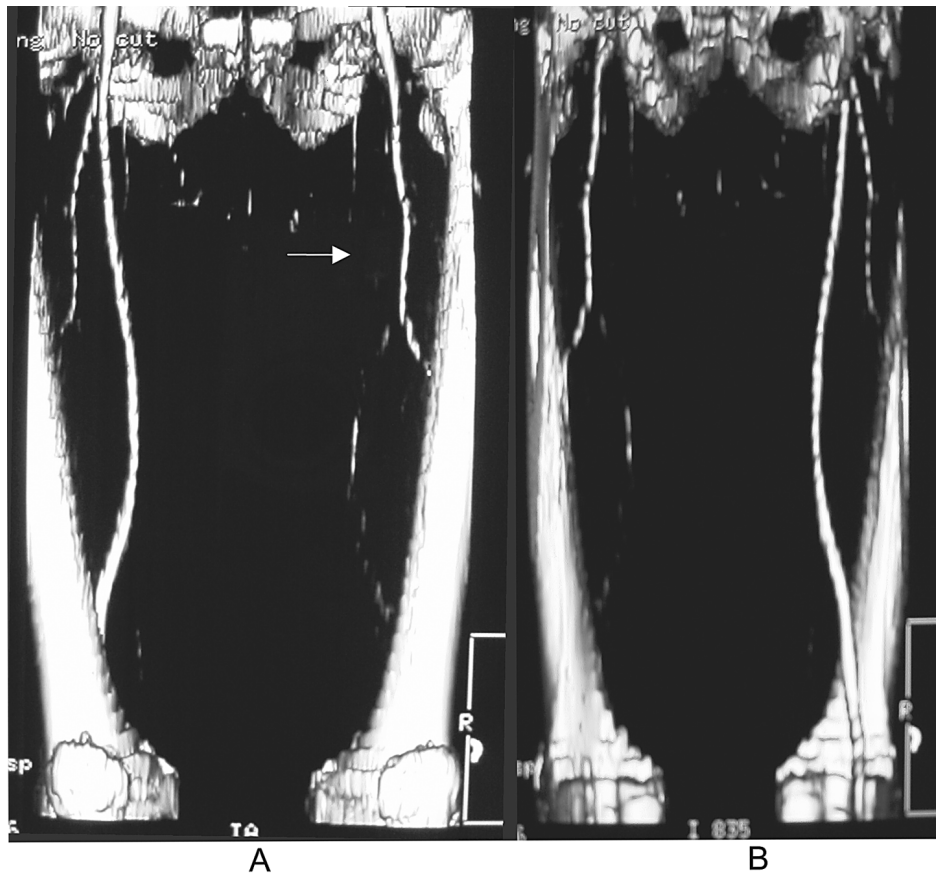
Maximum intensity projection computed tomography angiogram of the pelvic and femoral arteries.
